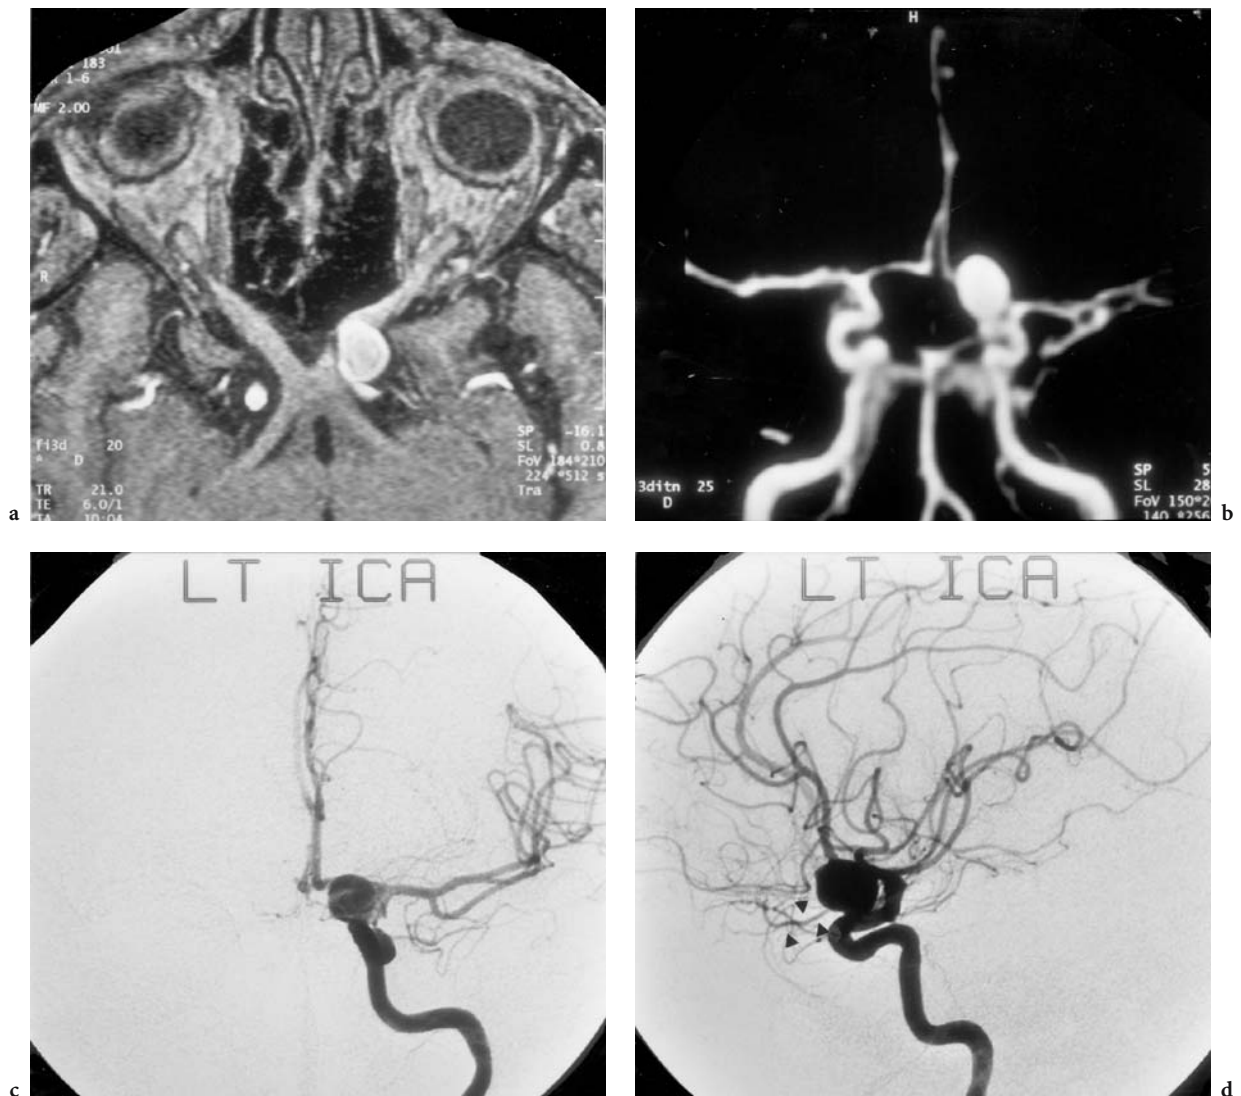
A 49-year-old woman with chronic headache, leading to imaging, no visual deficit, but signs of left optic nerve compression upon Goldman visual field examination. Diagnosis: incidental ophthalmic aneurysm of the left ICA. MRI: a Axial T1-weighted high resolution view (flash 3D) showing the impression of the left optic nerve at its proximal intracranial course by an anteriorly arising aneurysm at the origin of the ophthalmic artery. b MR-angiography (MIP reconstruction), demonstrating the superior extension of the lesion. DSA: c corresponding AP view of the left carotid artery injection. d Lateral view, where the origin of the aneurysm at the origin of the ophthalmic artery (*arrowheads*) is apparent
